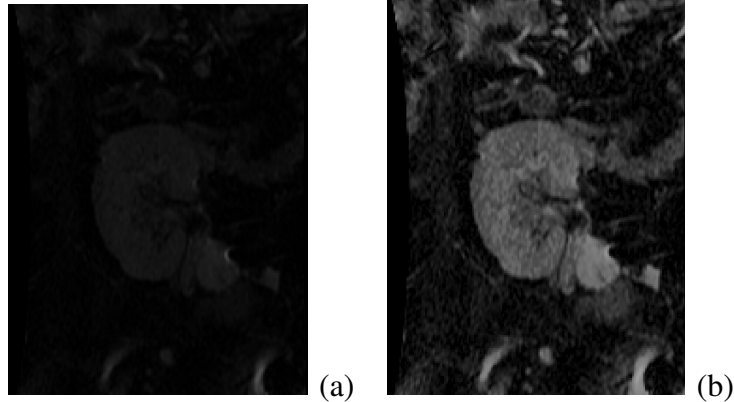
Raw coronal DW-MRI cross-section before (a) and after (b) its preprocessing.
